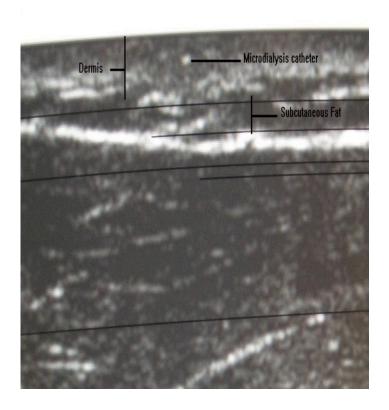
Ultrasound image of the skin and subcutaneous layers of the forearm following microdialysis probe insertion. Microdialysis probe, dermis and subcutaneous fat are indicated
